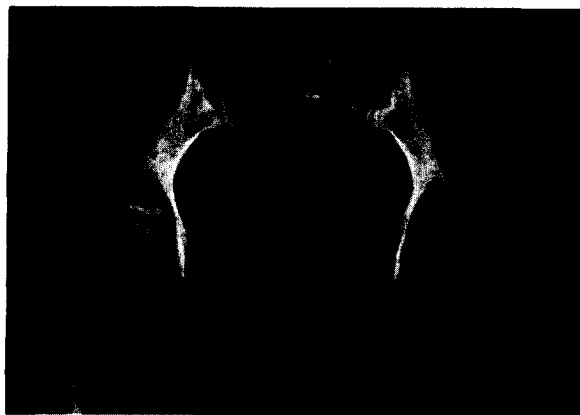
Pelvic radiograph taken 8 months after the onset of symptoms. Note the sclerosis of the margins of the pubic symphysis, as well as the joint narrowing.
